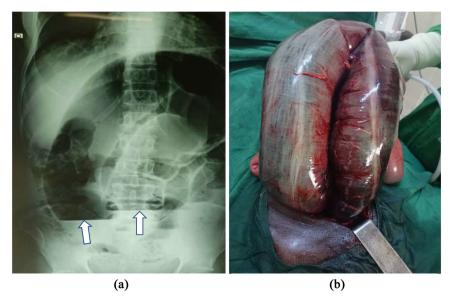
Necrotic volvulus of the sigmoid of a 67-year-old patient. (a) Double jamb hydro aerial images with staggered levels (white arrows) on unprepared abdominal X-ray. (b) Per-operative image of necrotic volvulus of the sigmoid.
